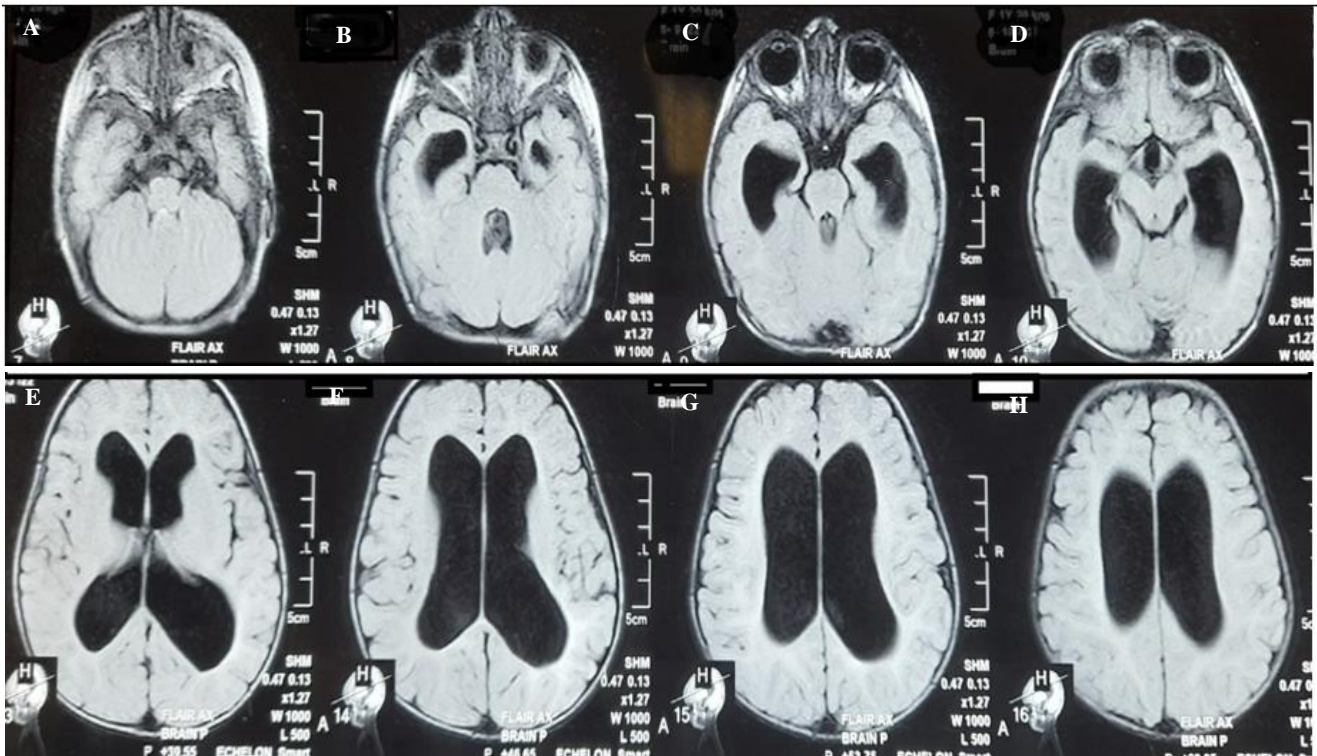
(A-H): Cranial computed tomography scan of the child showing ventriculomegaly (hydrocephalus).
